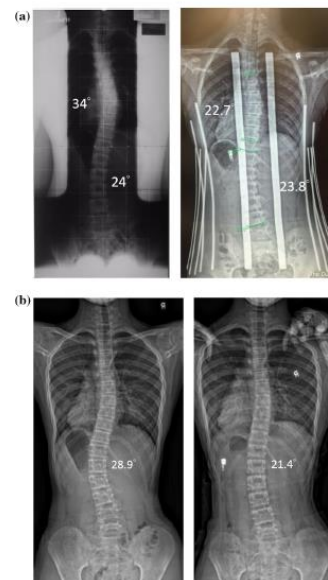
X-ray image of scoliosis subject before (left) and after (right) wearing posture correction girdle with (a) SMA supportive struts (b) RB supportive struts.
